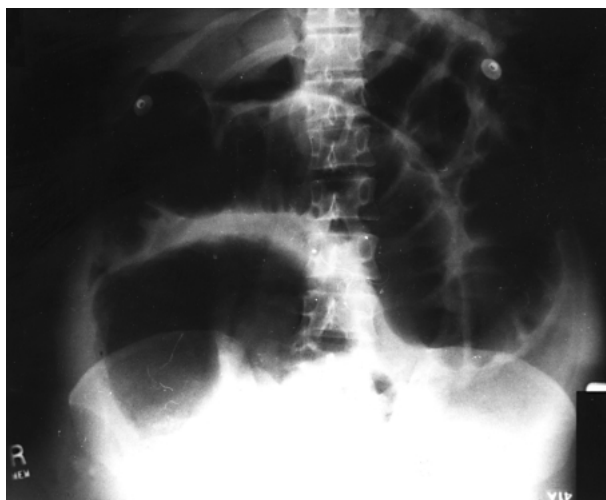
Supine abdominal radiograph of the case patient showing dilated loops of small bowel, pneumoperitoneum, an elevated diaphragm, intraperitoneal fluid, and obscured renal and psoas shadows.
